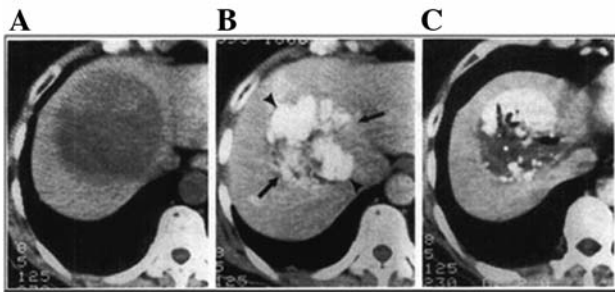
Multi-slice CT scans of an IT+MGN-3 patient. A: Before treatment, the patient had a large tumor in right liver measuring $12 \times 10 \text{ cm}^2$ in plane. B: At three months after treatment, the tumor size decreased to $7 \times 8 \text{ cm}^2$ in plane and had a very high lipiodol marking (arrows). C: At six months after treatment, the tumor size had decreased further to $6 \times 7 \text{ cm}^2$ in plane with lower lipiodol marking, showing liver regeneration.
